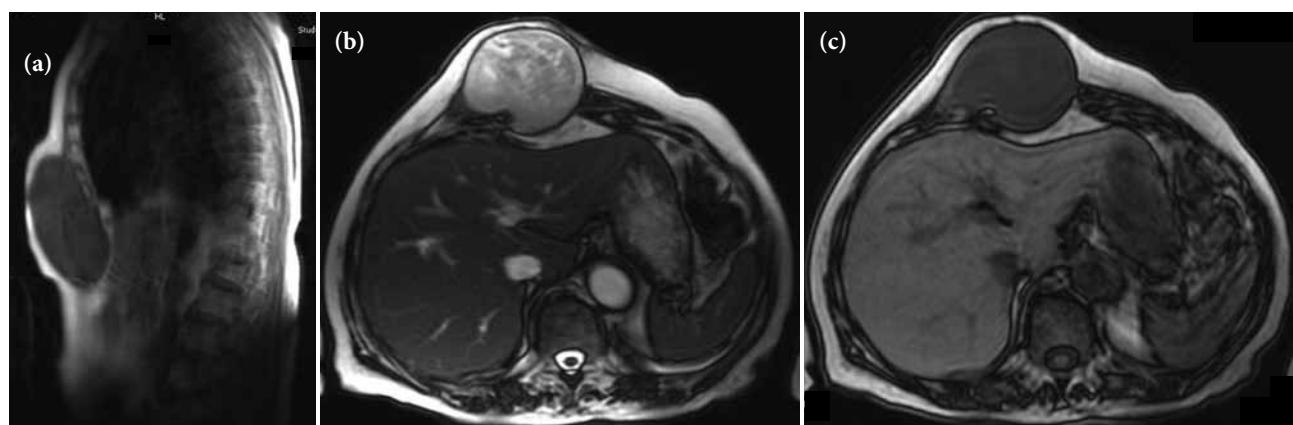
A 86-year-old female patient with a large desmoid tumour in the rectus abdominus muscle. The sagittal T1-w (a), axial T1-w (b) and axial True FISP T2-w (c), MR images, show the large lesion in the anterior abdominal wall, exhibiting low signal intensity on T1-w and inhomogeneously high signal intensity on T2-w images.
